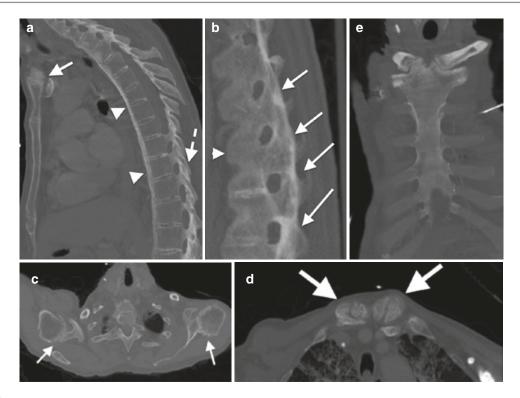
CT chest in a patient with chronic AS demonstrating typical chronic changes; (a) Sag reformatted image with extensive thoracic syndesmophyte formation (*arrowheads*), facet joint fusion (*dashed line*) and sternoclavicular joint erosion and subchondral sclerosis (*arrow*); (b) magnified from (a) with syndesmophyte formation (*arrowhead*), facet joint fusion (*arrows*), (c)
